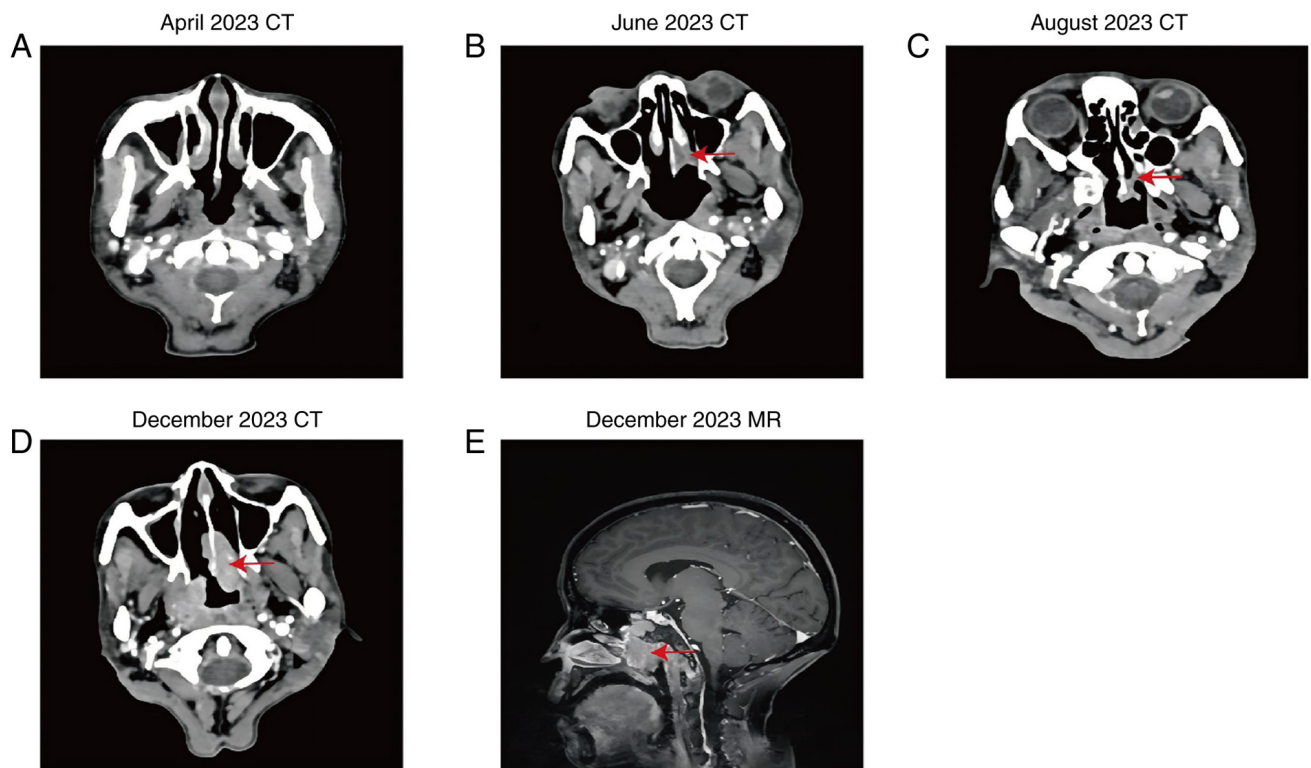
Imaging characteristics of breast cancer with nasopharyngeal metastasis at different stages. (A) Normal nasopharyngeal CT imaging. (B) Contrast-enhanced CT scan revealing a soft-tissue mass in the nasopharynx (arrow). (C) Partial regression of the mass (arrow) following treatment. (D) Progressive soft tissue thickening with heterogeneous enhancement (arrow). (E) MR imaging showing an enlarged nasopharyngeal mass with irregular density (arrow). CT, computed tomography; MR, magnetic resonance.
